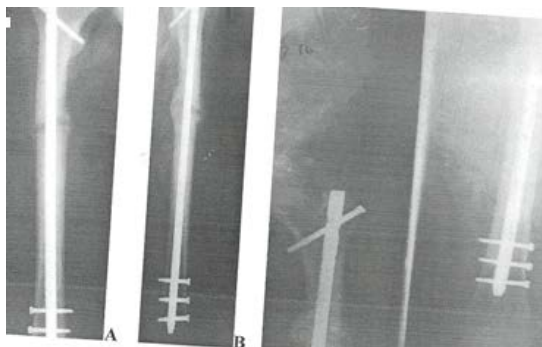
X-rays of non-comminuted fracture
